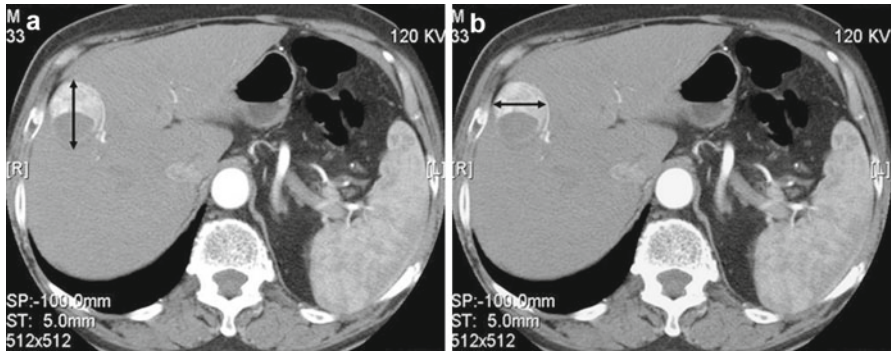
Use of mRECIST criteria in the assessment of HCC responses to therapy. Target tumor response measurements on arterial-phase CT scans. (a) Measurement of greatest overall tumor diameter according to conventional RECIST criteria and (b) measurement of greatest viable tumor diameter according to the mRECIST method for HCC (Used with permission from Lencioni and Llovet [29])
